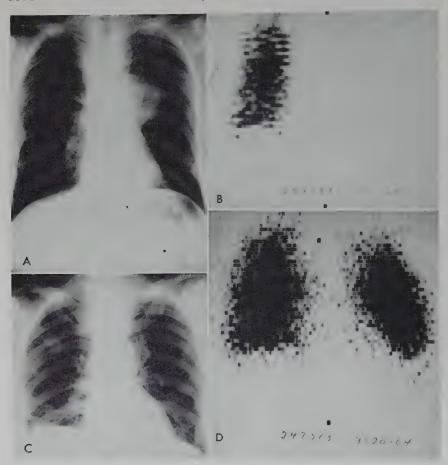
A, Mass in the left hilum with pleural metastasis bilaterally and involvement of the anterior end of the right second rib. B, Lung scan, though technically poor, demonstrates no pulmonary artery blood flow to the left lung. C, Roentgenogram six weeks after completion of radiation therapy to the mediastinum and left hilum demonstrating regression of the left hilar lesion but progression of other metastatic lesions. D, Lung scan shows return of pulmonary artery perfusion to the left lung six weeks after radiation therapy.
